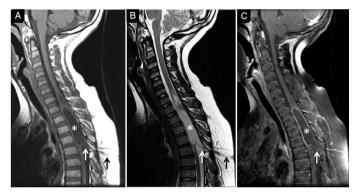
Sagittal Magnetic resonance images of the cervical and upper thoracic spine in a 14-year-old boy with DSCI in the dorsal region(Case 2). The DS tract in the subcutaneous (black arrows) and intradural (white arrows) cellular tissue with an intramedullary dermoid cyst (asterisk) can be identified. A. MRI in T1. B. MRI in T2. C. MRI in T1 with fat suppression and gadolinium.
